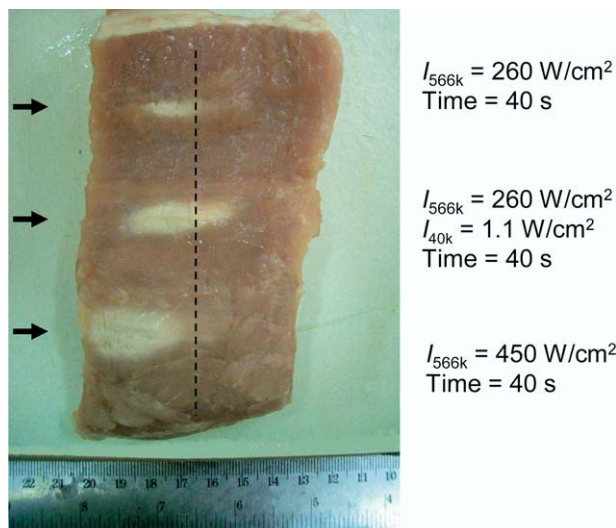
Comparison of the thermal lesions generated in three conditions: 260-W/cm², 566-kHz ultrasound alone (top); combined 260-W/cm², 566-kHz and 1.1-W/cm², 40-kHz ultrasound (middle); and 450-W/cm², 566-kHz ultrasound alone (bottom). In all cases the exposure time was 40 s. Vertical dashed line indicates the focal depth of the 566-kHz transducer.
